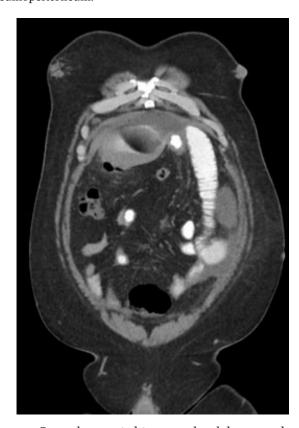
Coronal computed tomography abdomen and pelvis with oral contrast showing obstructed small bowel.
